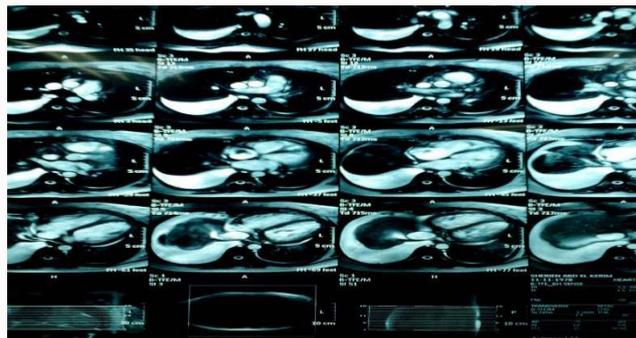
MRI heart showed right atrial mass.
